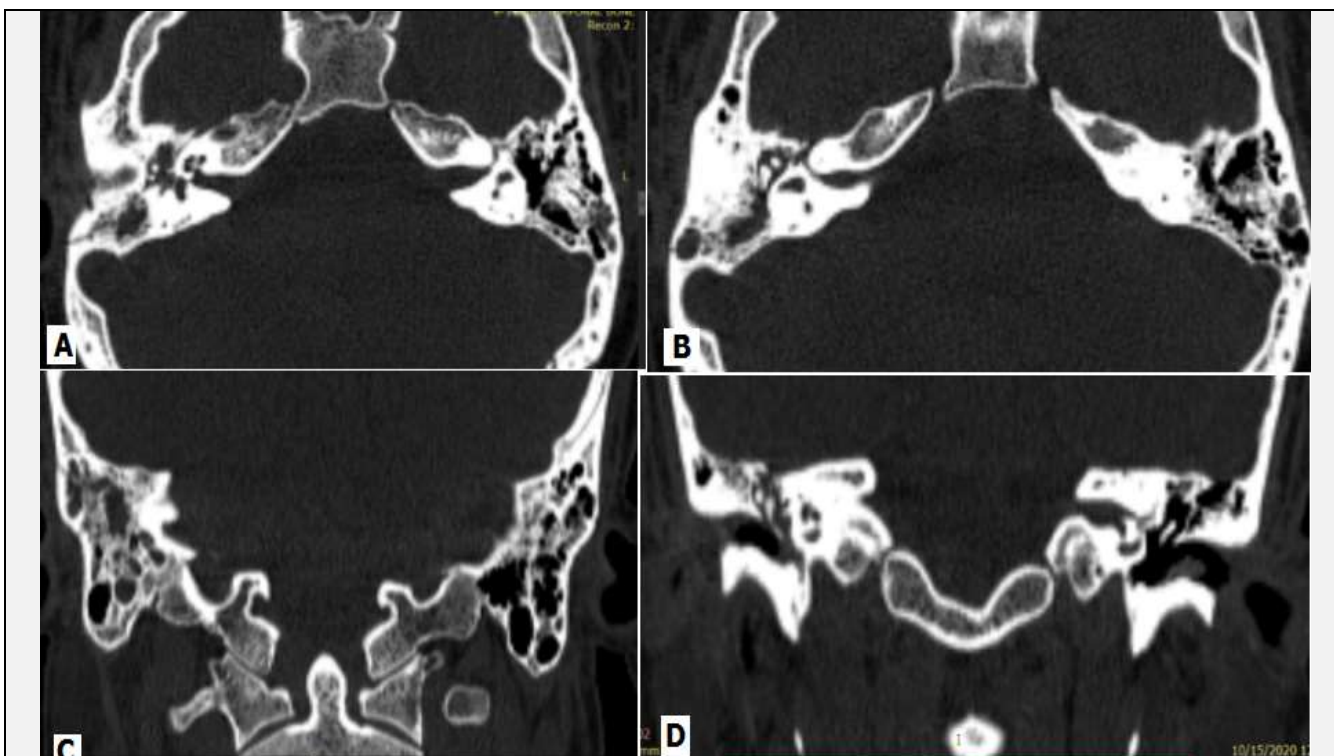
(a) and (b) Shows Axial Images, (c) and (d) Coronal Reformatted Sections and of HRCT Temporal Bone of a 25 Year Old Male Who Had Presented Following a Road Traffic Accident with Longitudinal Fracture of Petrous Part of Right Temporal Bone with Associated Right Sided Hemotympanum, Hemomastoid and Dislocation of the Right Incudomalleolar Joint
